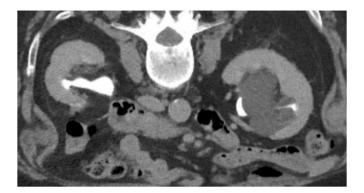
Four months post-op CT scan displaying renal pelvis and ureter filling with no evidence of obstruction and no recurrence of the parapelvic cyst.
